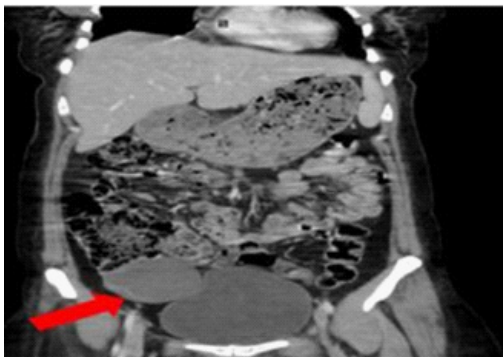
Contrast-enhanced pelvic CT scan demonstrating a well-circumscribed nodular lesion (66x60 mm) in the right adnexal region, containing areas of adipose tissue and calcified densities (red arrow), suggestive of ovarian teratoma.
